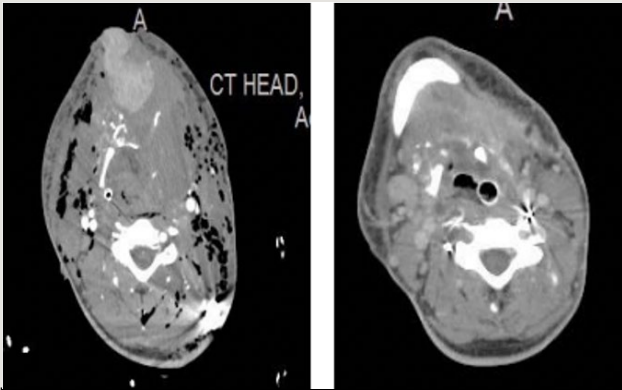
CT scan at admission (left) and discharge (right)
